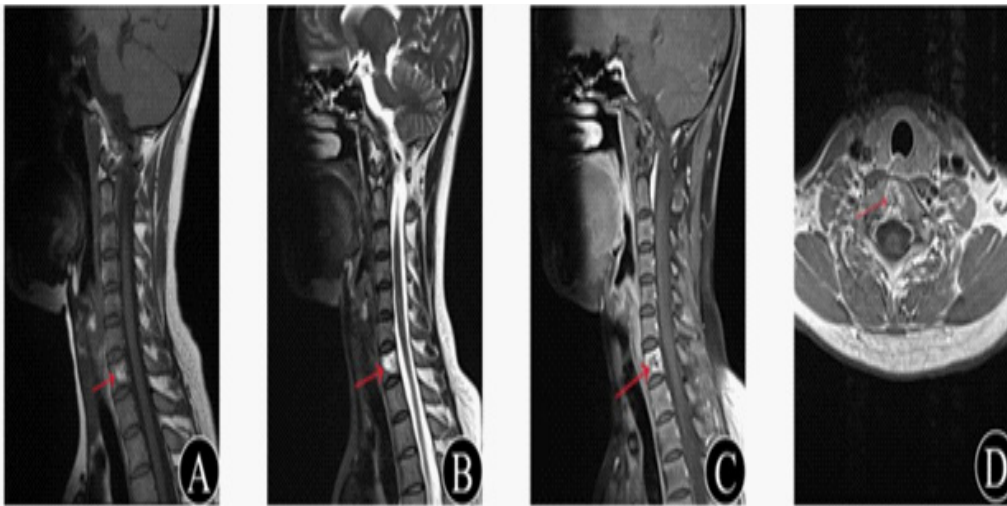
(A-D) MRI of the cervical spine showed abnormal C7 signal, patchy short T1 and long T2 signal shadows in the lesions, patchy long T2 signal shadows on contrast-enhanced MRI, and uneven enhancement on contrast-enhanced scanning.
